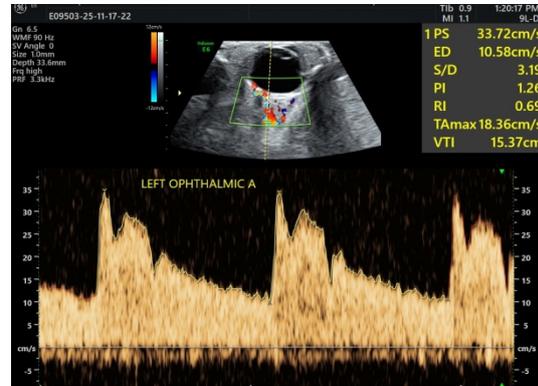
Spectral Doppler waveform of the left ophthalmic artery showing low-resistance flow with elevated systolic velocities. Measured parameters include PSV 33.72 cm/s, EDV 10.58 cm/s, PI 1.26, and RI 0.69.
